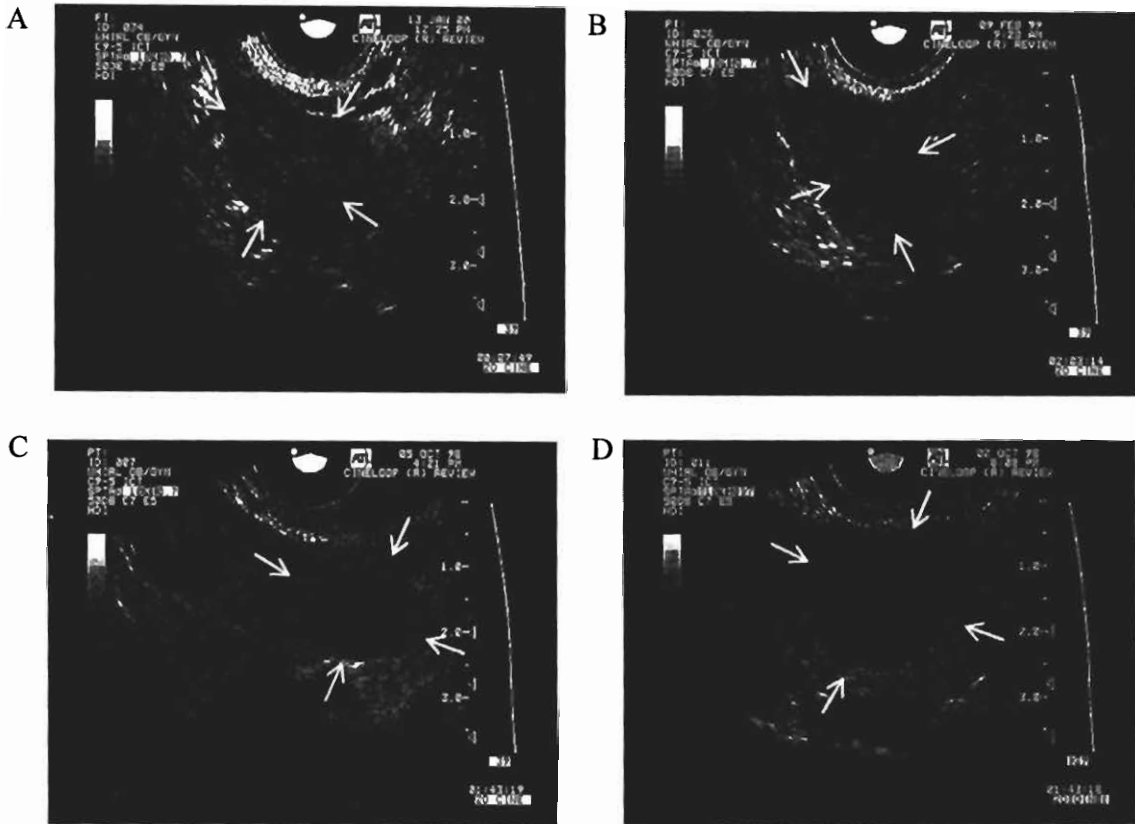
Ultrasonographic images of corpora lutea with no central fluid-filled cavities (A) and small (B), medium (C) and large (D) fluid-filled cavities. Arrows delineate the outer borders of the CL.
